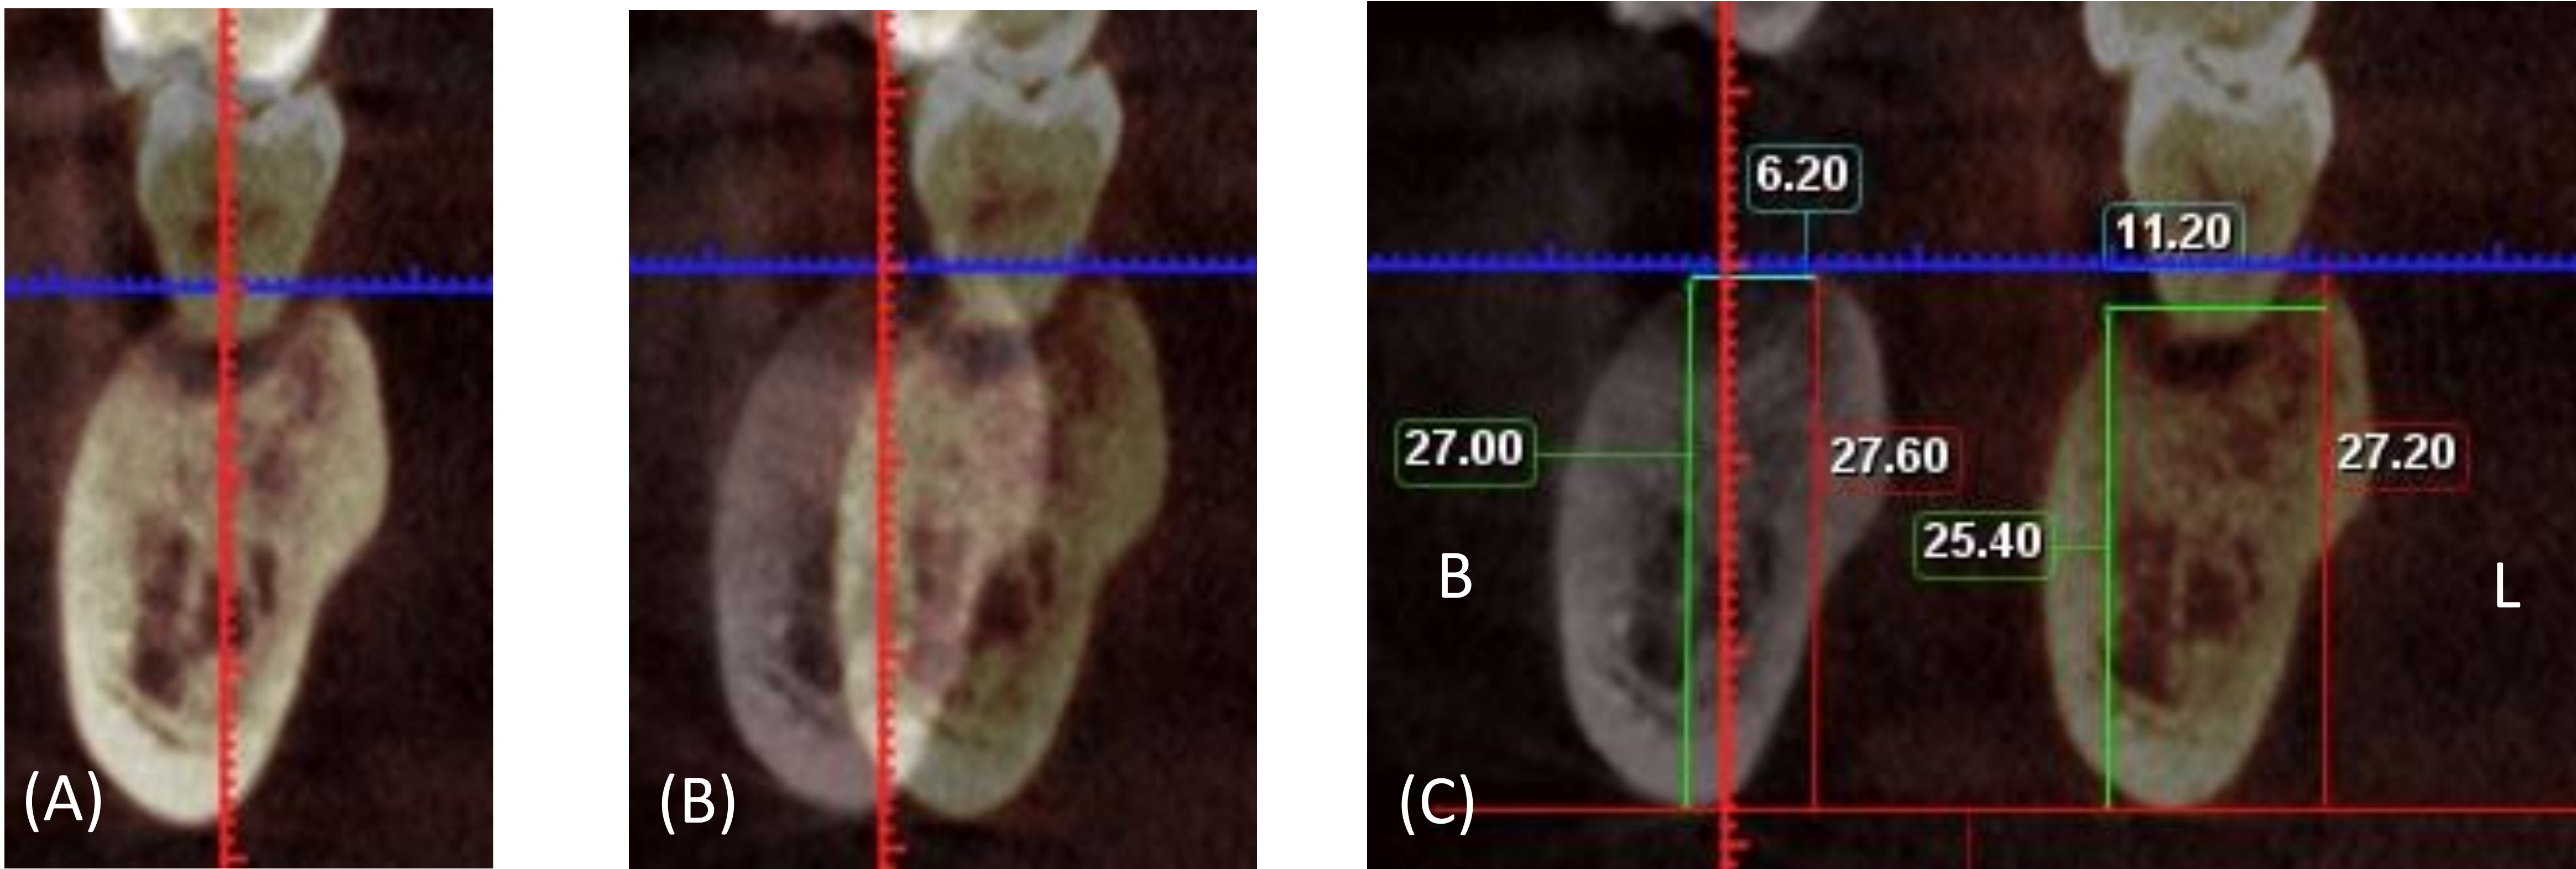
CT: (A) Overlay the baseline image with the 4-month postoperative image (B) Image superimposition (C) Dimensional measurement
